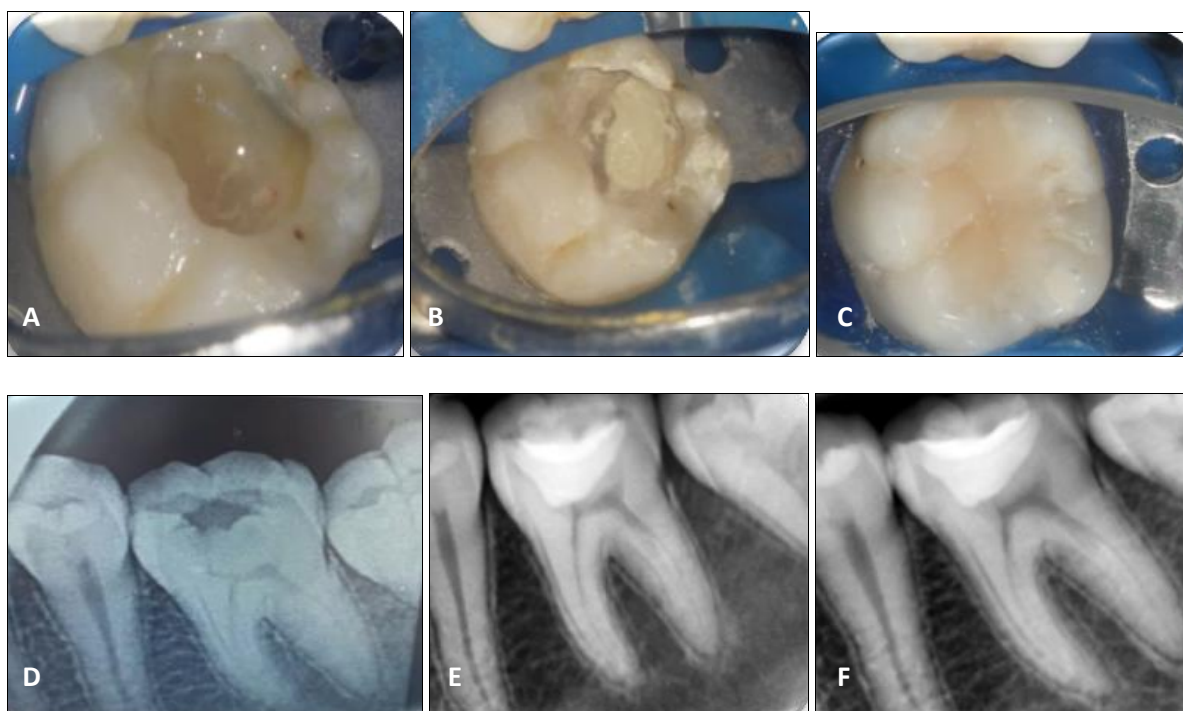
(a) APRF+ placed (b)MTA placed (c)Post op clinical picture (d)Pre-op radiograph (e) Follow up radiograph at 3 months (f) Follow up radiograph at 12 months
